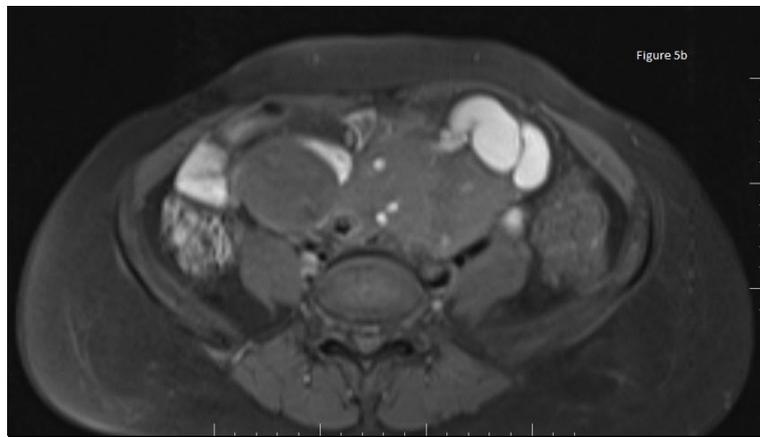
MRI – showing bilateral dilated fallopian tubes due to blood appearing hyperintense on axial T1 FATSAT.
